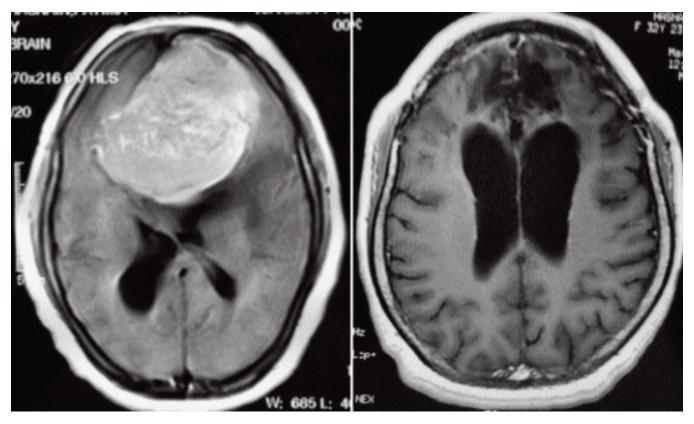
Figure (a,b): Pre and post operative MRI brain with contrast, axial sections, showing complete excision of a large frontal meningioma that was diagnosed due to symptoms of depression.
